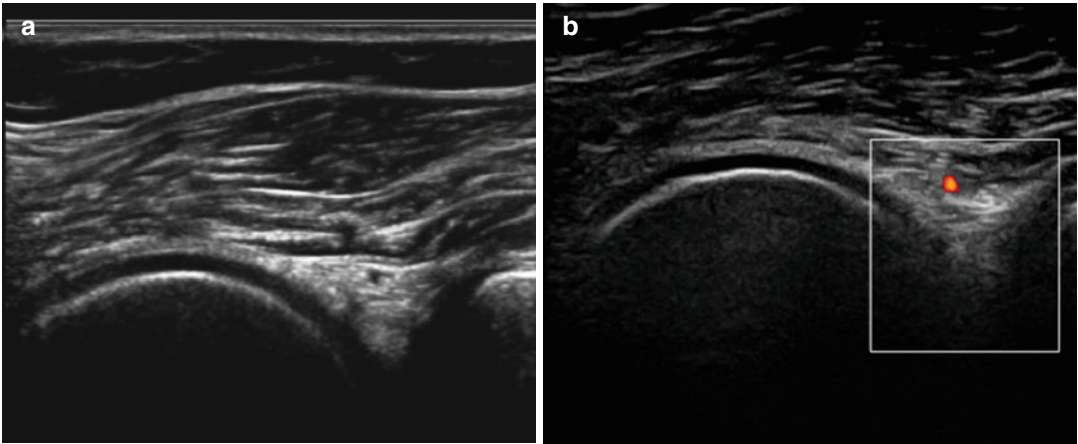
(a) Posterolateral meniscus (b) Vascular Doppler technology
